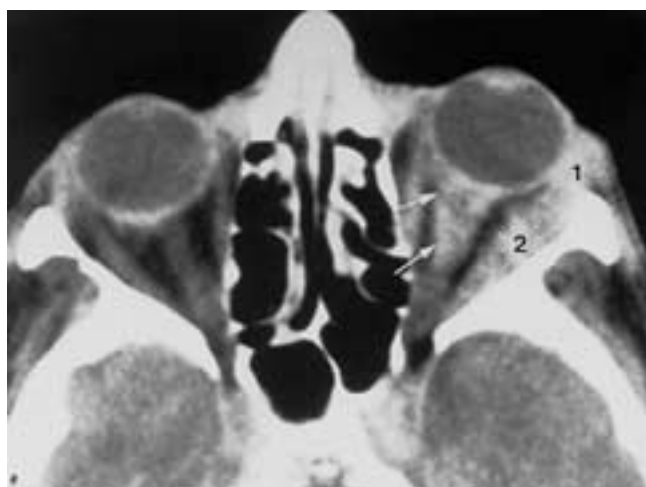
Lymphoma. Postcontrast axial CT scan shows an infiltrative process involving the left lacrimal gland (1), lateral orbital compartment (2), and perioptic nerve region (arrows).
